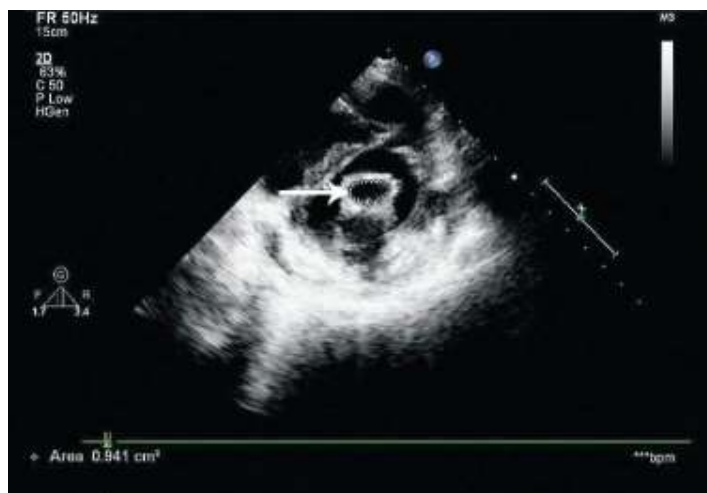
Transthoracic echocardiography confirmed revealed severe mitral stenosis with thickened mitral valve leaflets (ARROW)
